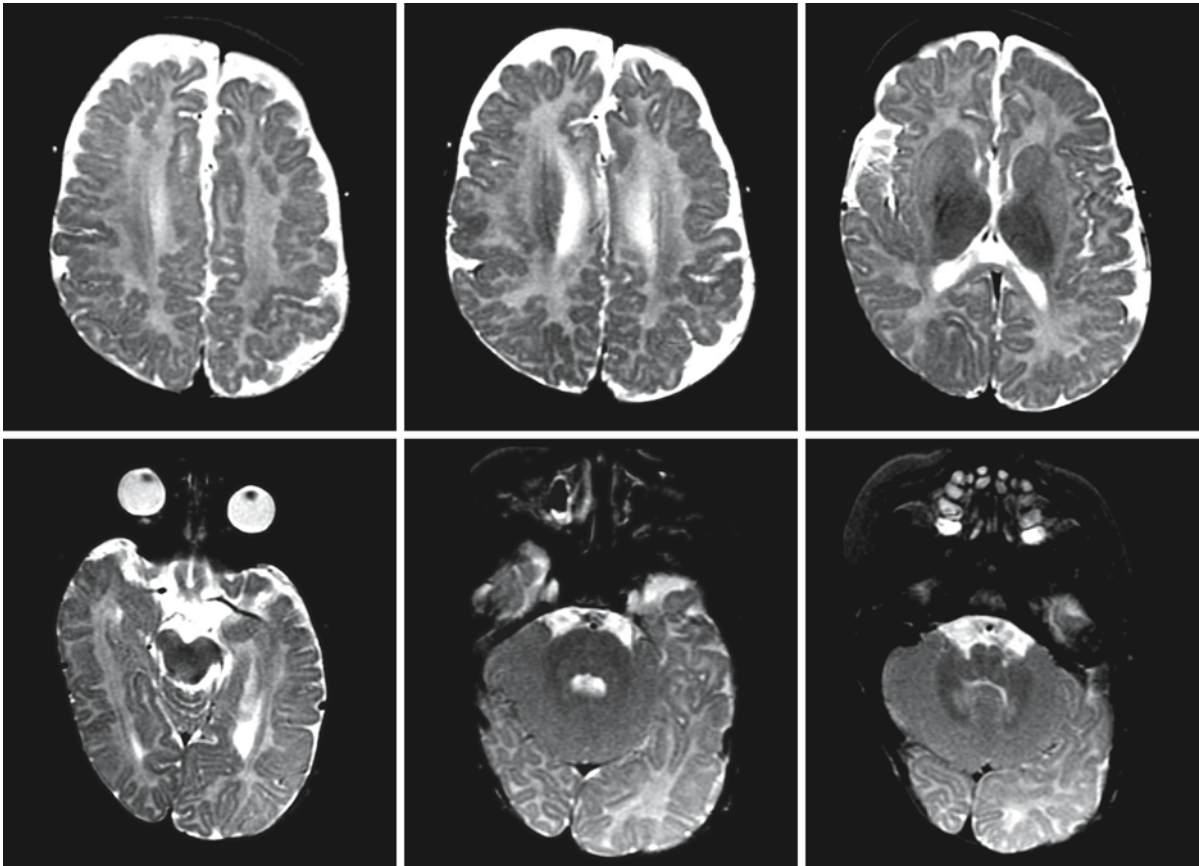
Follow-up MRI of the same boy with BPD at the age of 6 months. The polymicrogyria in the perisylvian region is again visualized. The brain stem is now well myelinated, but there is little myelin in the supratentorial white matter. Note
